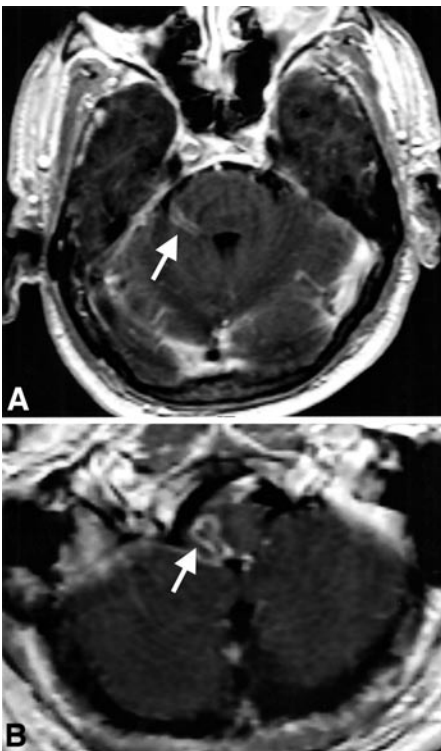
Additional patient successfully treated for *Listeria* brain stem encephalitis (2). T1-weighted Gadolinium-enhanced MRI. A. Transverse section showing contrast enhancement along the pathway of right Vth nerve. B. Transverse section showing contrast enhancement in the region of the 12th cranial nerve nucleus, solitary tract and spinal trigeminal nucleus in the right medulla oblongata.
